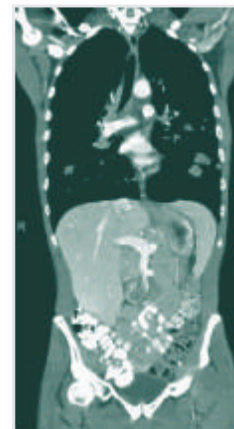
Whole body CT – coronal reformat
